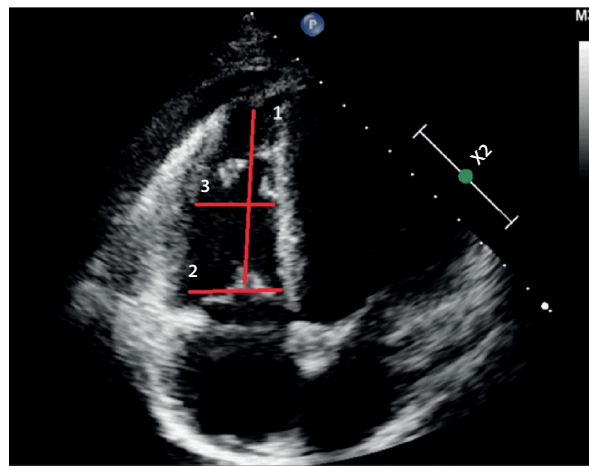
Image obtained through apical four-chamber view showing (1) longitudinal axis, (2) basal diameter and (3) medium diameter.
